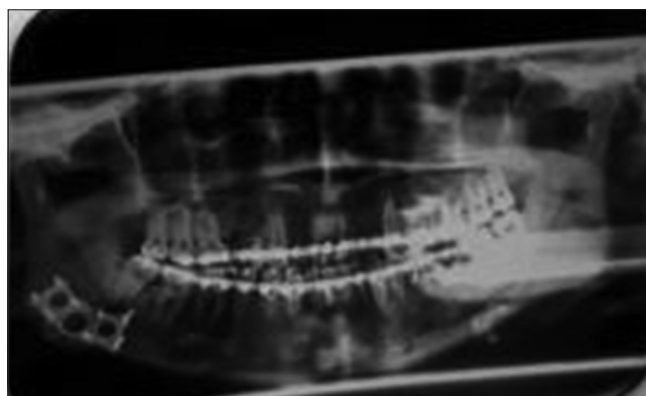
Post-operative orthopantomogram
